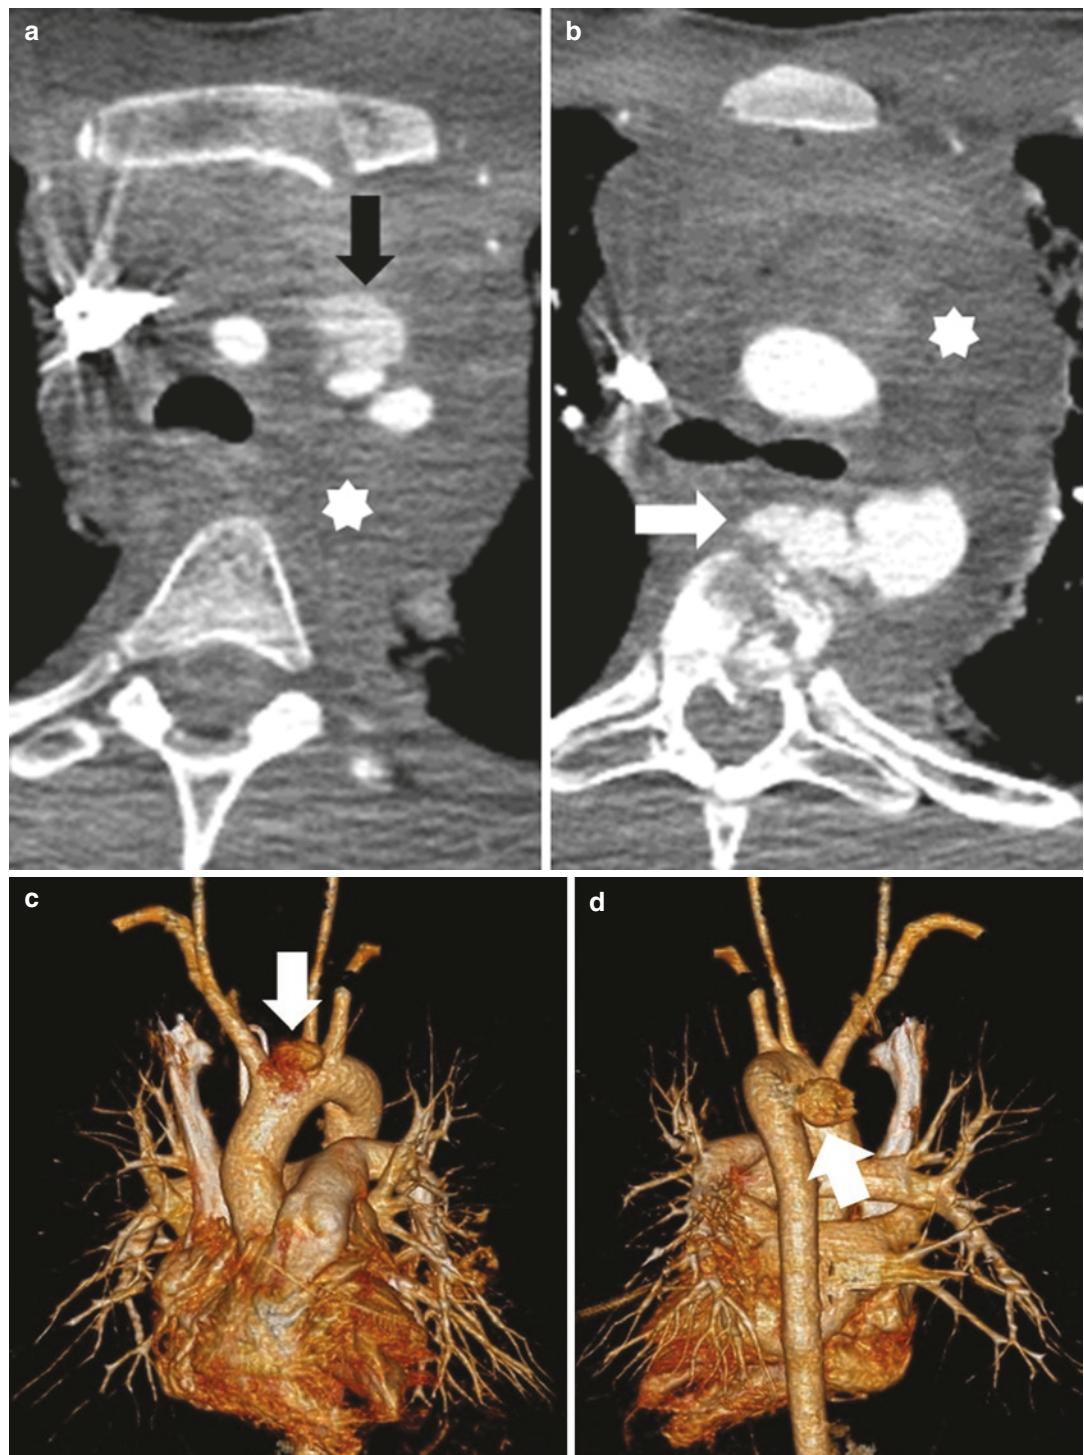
Nineteen-year-old man presenting after a gunshot wound to the thoracic aorta and spine. Axial IV contrast-enhanced CT image (a, b) show active extravasation of contrast from the aortic arch/left common carotid artery junction (black arrow), contained rupture of the descending aorta with pseudoaneurysm (white arrow), and mediastinum hematoma (asterisks). 3D reformatted images demonstrate the aortic
